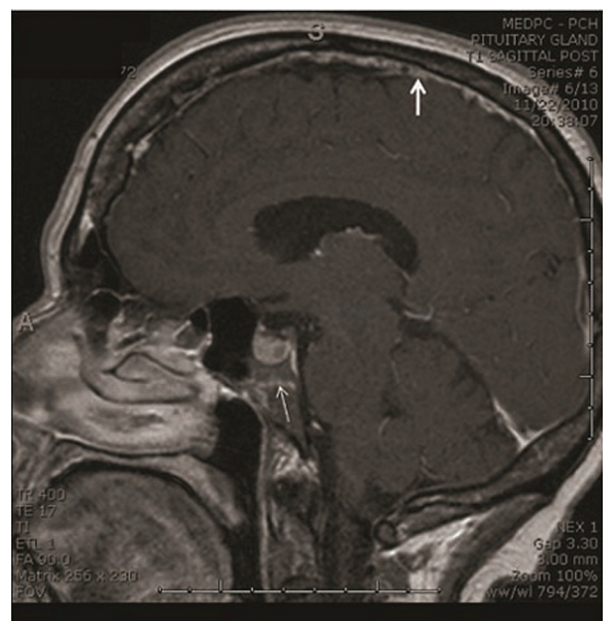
Sagittal section postcontrast T1-weighted brain MRI image showing the dural thickening with gadolinium-contrast enhancement (thick arrow) and the bone marrow signal enhancement in the clivus (thin arrow).
